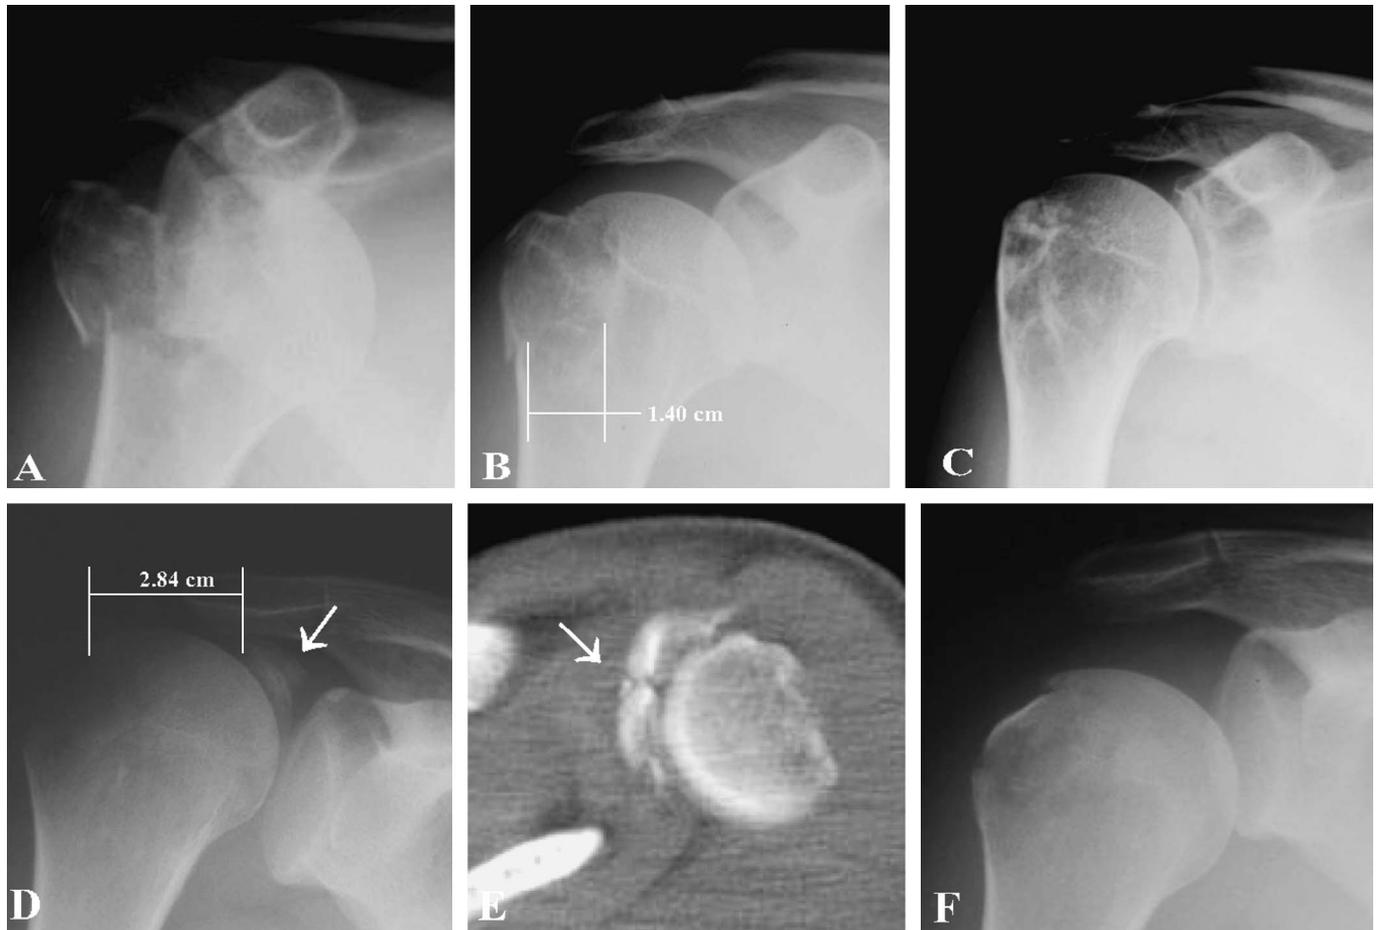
A, Anterior shoulder dislocation associated with a GT fracture in a 32-year-old patient. B, Postreduction GT displacement is measured at 1.4 cm in the standard anteroposterior view. C, Solid union and excellent clinical outcome (Constant score 100) 5.5 years postoperatively. D, Another patient with avulsion and retraction of the GT fragment after reduction of the dislocation (arrow). The postreduction displacement is measured at 2.84 cm. E, CT scan demonstrates the degree of fragmentation and a hidden, posteriorly displaced, GT fragment (arrow). F, Reduction and fixation was achieved with sutures; both the supraspinatus and infraspinatus tendons were avulsed from their facets.
